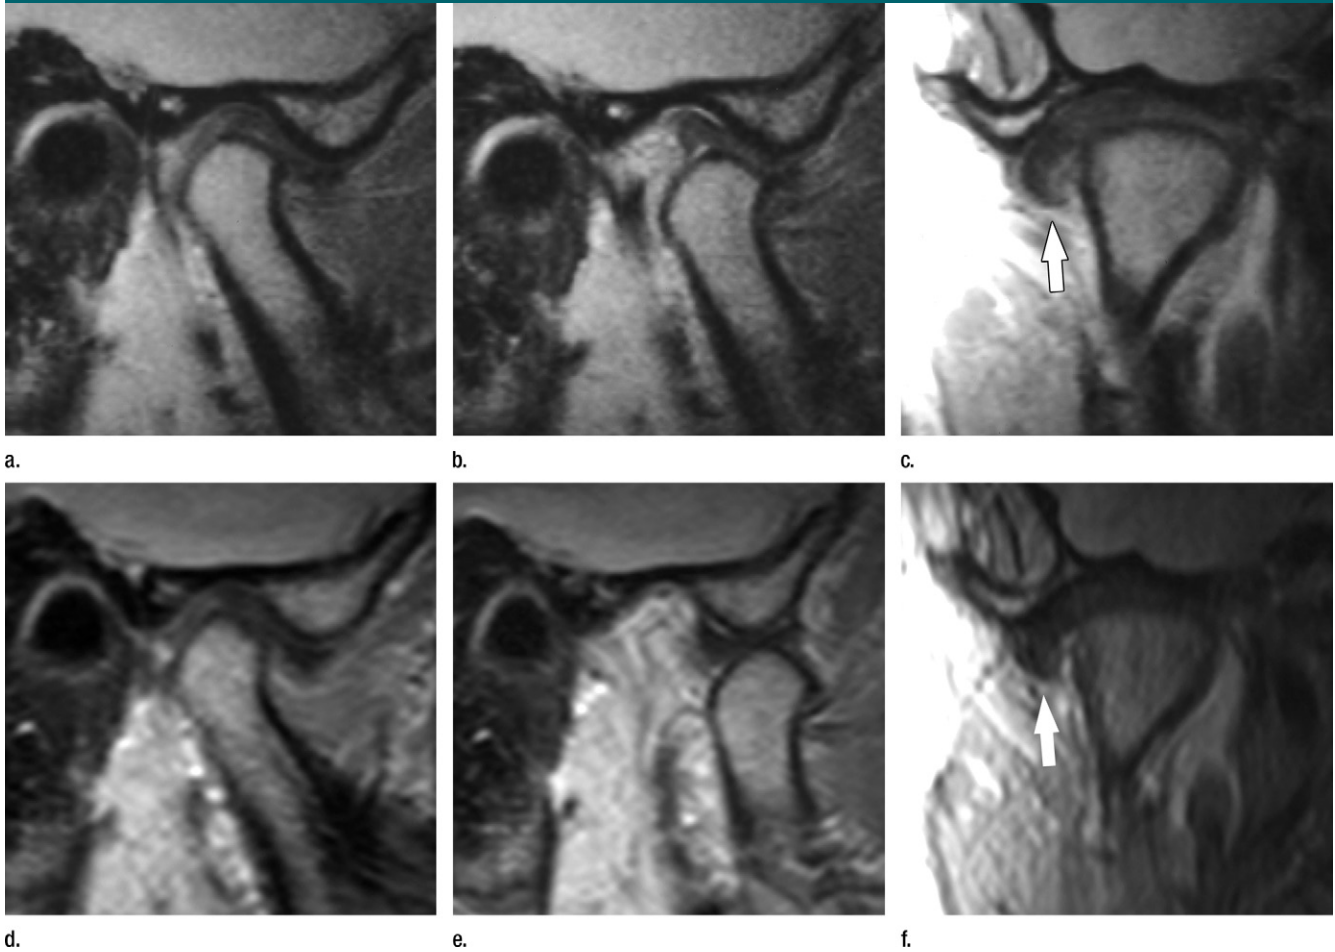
MR images of lateral TMJ disk displacement with reduction (arrows, c, f) at inception and at 15-year follow-up in a 42-year-old man (27 years old at study inception). Proton density-weighted sagittal images (2199/17) were obtained at inception in (a) closed-mouth and (b) open-mouth positions, and (c) coronal image (2000/17) was obtained in closed-mouth position. (d–f) Corresponding images at 15-year follow-up (4000/19, sagittal images; 3200/19, coronal images) show maintained TMJ status. Note the similarity between images obtained in both sagittal and coronal imaging planes at the differing time points.
